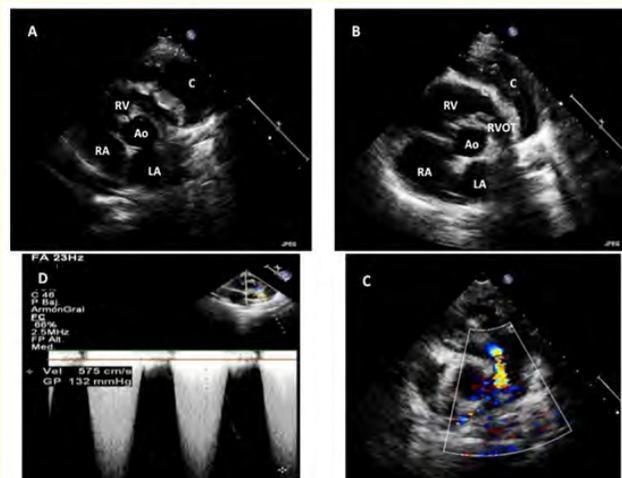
Echocardiography: A and B) Short axis view at the level of the right ventricular outflow tract (RVOT). Great collection (C) in the anterior wall of the right ventricle (RV) with obstruction of the RVOT that is seen with color aliasing (C) and measured with continuous Doppler wave that shows a severe obstruction D).
